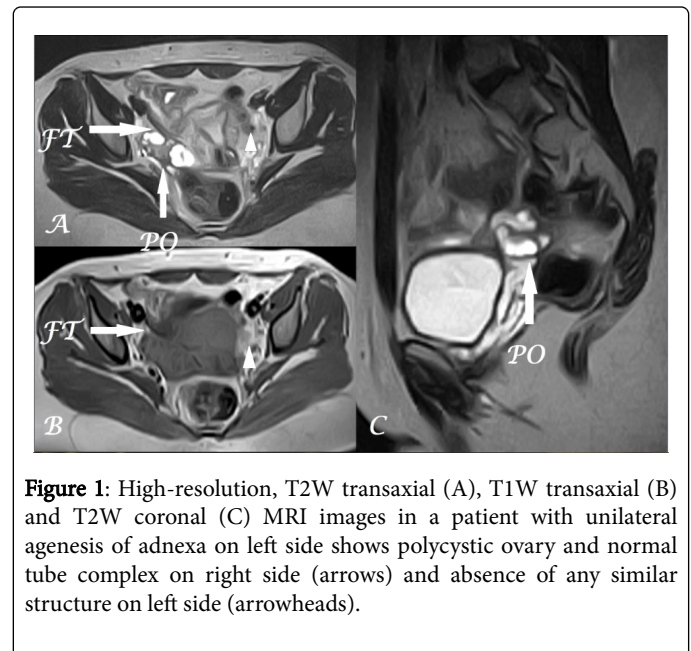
High-resolution, T2W transaxial (A), T1W transaxial (B) and T2W coronal (C) MRI images in a patient with unilateral agenesis of adnexa on left side shows polycystic ovary and normal tube complex on right side (arrows) and absence of any similar structure on left side (arrowheads).
